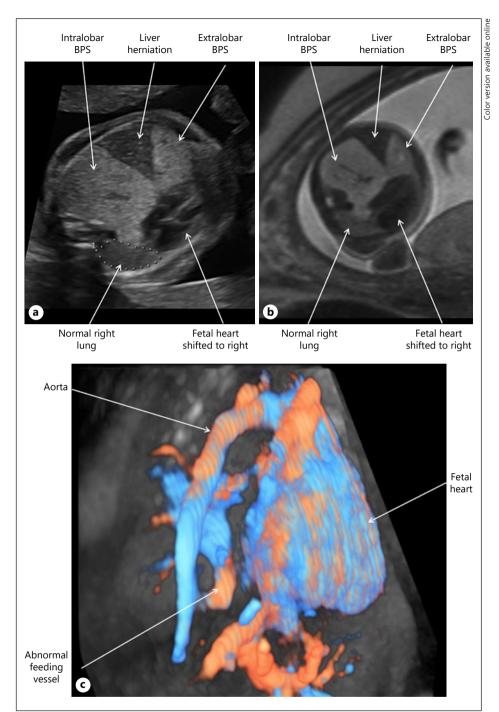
a Two-dimensional ultrasound imaging of a cross-sectional view of the fetal chest at the 4-level chamber view at 22 weeks of gestation showing a large posterior intralobar BPS, liver herniation caused by CDH in the middle, and a small anterior extralobar BPS associated with severe mediastinal shift in a fetus at 22 weeks of gestation. b Fetal magnetic resonance imaging of a crosssectional view of the fetal chest at the 4-level chamber view at 22 weeks of gestation showing a large posterior intralobar BPS, liver herniation caused by CDH in the middle, and a small anterior extralobar BPS associated with severe mediastinal shift in a fetus at 22 weeks of gestation. c Three-dimensional color Doppler ultrasonography showing a large abnormal pulmonary sequestration feeding vessel from the aorta artery. BPS, bronchopulmonary sequestration; CDH, congenital diaphragmatic hernia.
